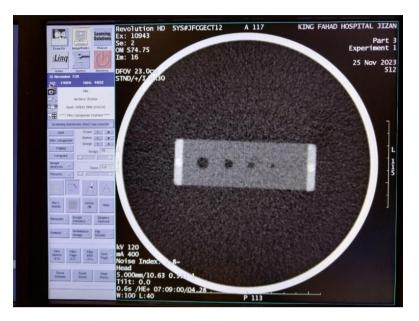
The CT image of the first section with the high parameters of the experiment.
